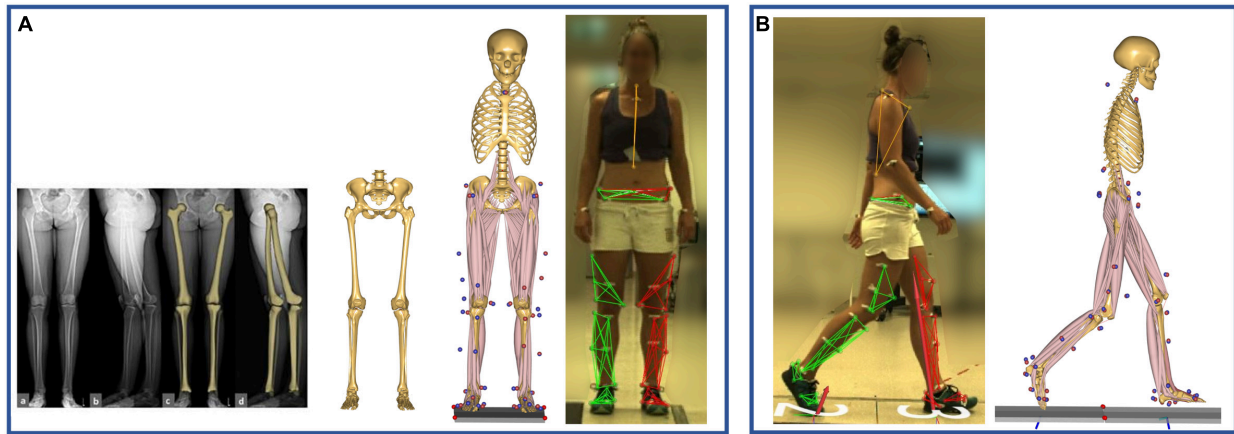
(A) Model scaling and personalization based on subject-specific radiographic measurements, obtained through a low-dosage biplanar EOS system (EOS Imaging Inc., France). The distance between the hip joint centers, measured in the frontal plane, was used to scale the pelvic width, while the femoral torsion was calculated through 3D reconstructions of the femurs (sterEOS software, EOS Imaging Inc., France). The model was scaled to match the subject's anthropometrics based on marker data collected during a standing reference trial. (B) Kinematic and kinetic analyses during gait were based on the tracking of the measured marker trajectories.
